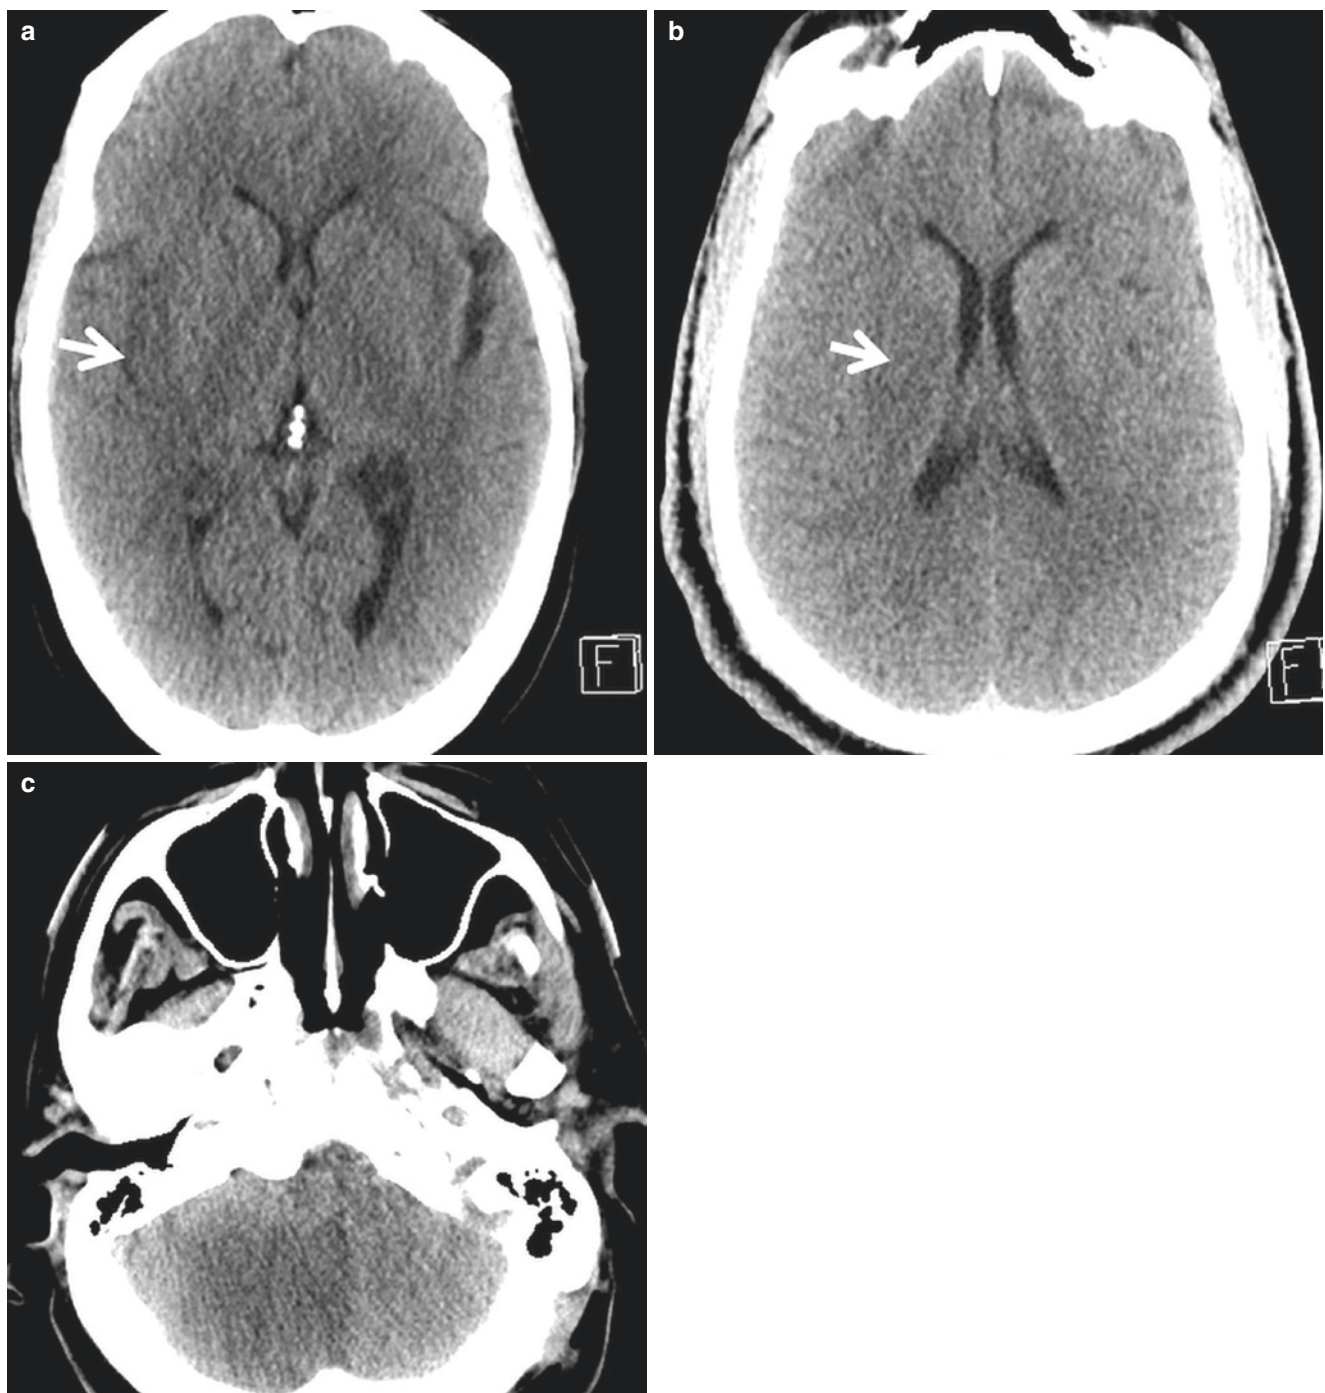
CT findings of acute ischemic stroke. (a), NCCT shows loss of gray–white matter differentiation of right insula. (b), NCCT in a different stroke patient shows hypodensity in the right lentiform nucleus. (c), NCCT shows hypodensity of right cerebellum
